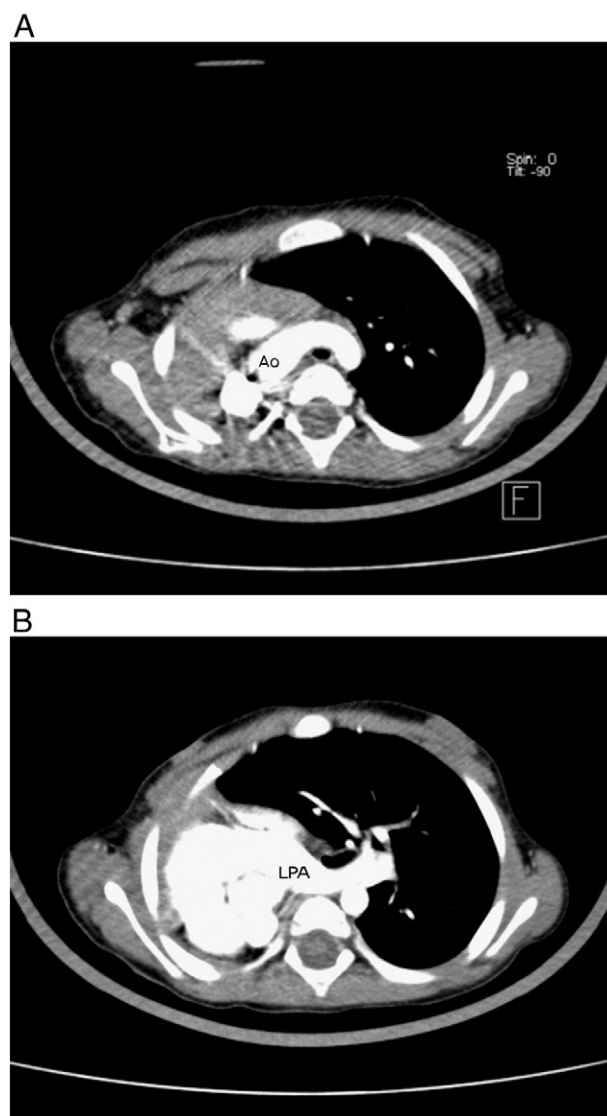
Preoperative axial multidetector CT view in the second patient. A, The aortic arch, which is rotated and displaced to the right, can be seen to cross the trachea anteriorly. B, The aberrant LPA runs behind the trachea. Ao indicates aorta.
